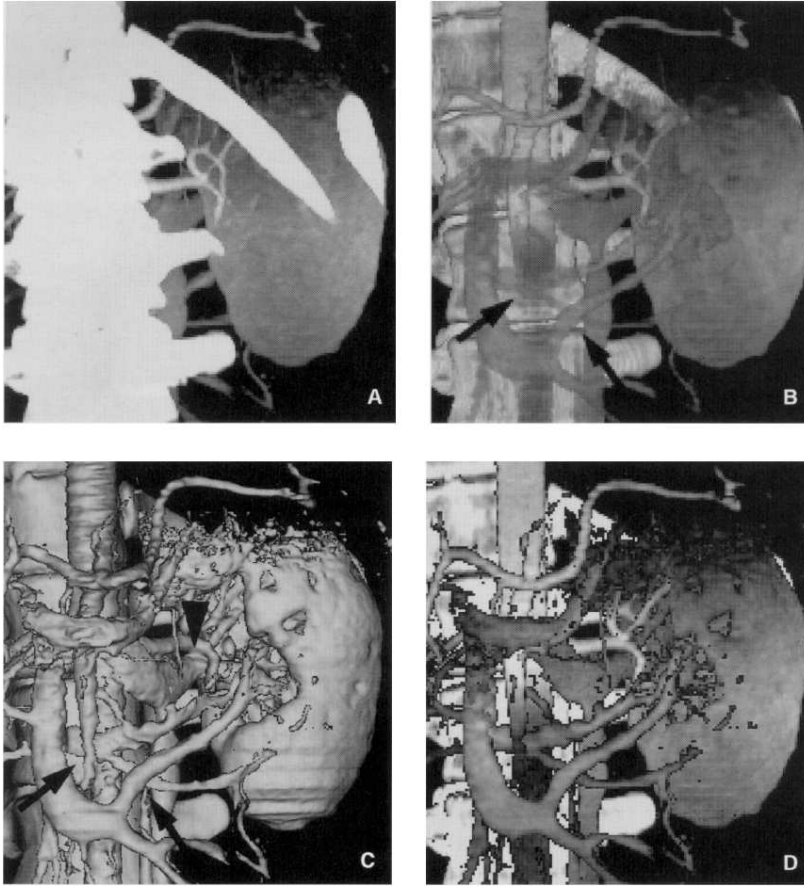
Visualisation of a CT angiography dataset of a kidney. A: MIP. B: volume rendering. C: Mesh rendering/surface visualisation. D: LMIP. Image from Sato et al., Local Maximum Intensity Projection (LMIP): A New Rendering Method for Vascular Visualization *Journal of computer assisted tomography*, LWW, 1998, 22, 912-917. Used with permission from Wolters Kluwer Health, Inc.
